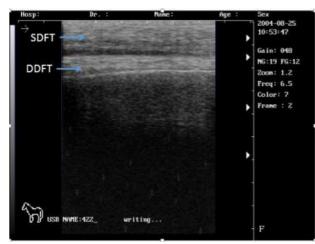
Ultrasound longitudinal image for the tendons of bone marrow treated group at 60 days post operatively indicates corresponding longitudinal view fiber alignment grade.
